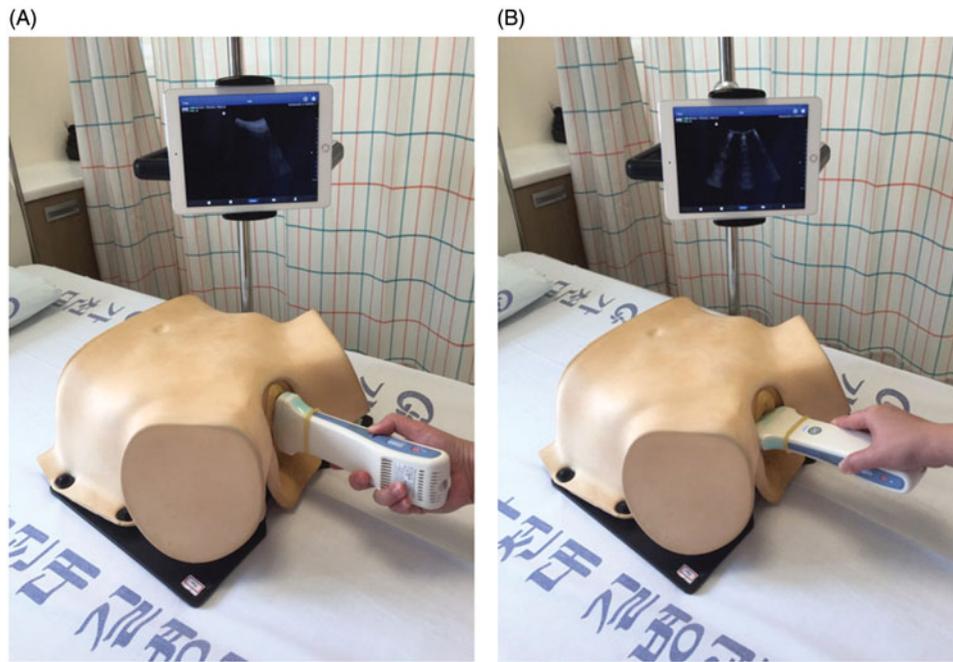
Transperineal sonography with SONON. (A) Transperineal sagittal approach. (B) Transperineal transverse approach.
